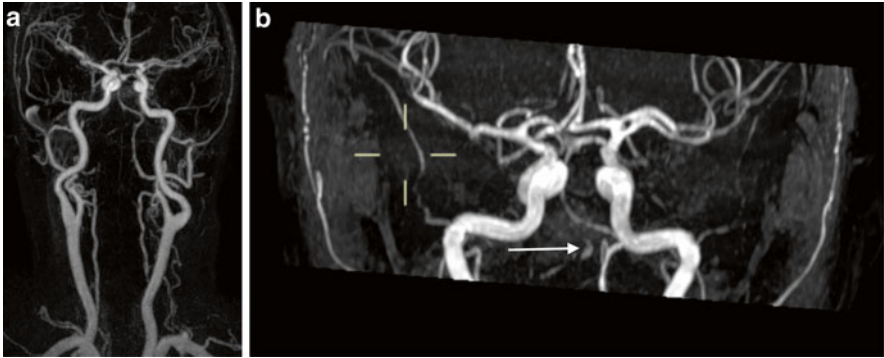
Contrast-enhanced MRA. (a) Thick-slab MIP image from contrast-enhanced MRI of cervical and intracranial arteries. The right intracranial VA shows no opacification. (b) Thick-slab MIP image from 3D TOF MRA in the same patient performed at the same time as (a). There is high signal visible in the right VA. This was subsequently shown to be hyperintense on T1 imaging, indicating that this is intravascular thrombus, and not flow-related signal. The underlying cause in this case was thought to be arterial dissection
